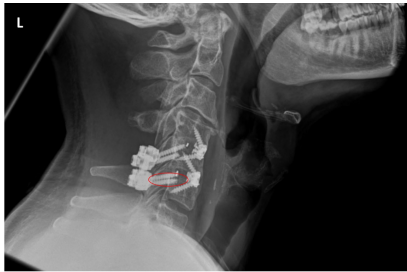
A plain radiograph showing intra-articular facet breach.
